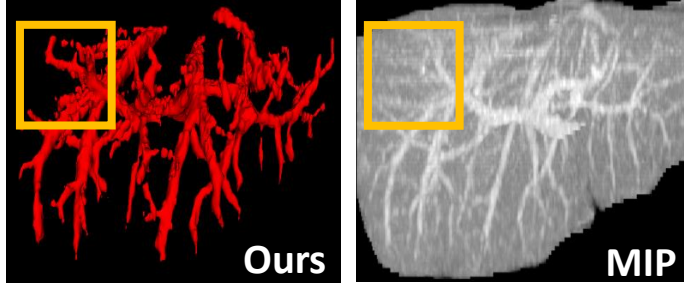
Failure analysis. Correctly segmenting low-contrast CT images is challenging for our method.
